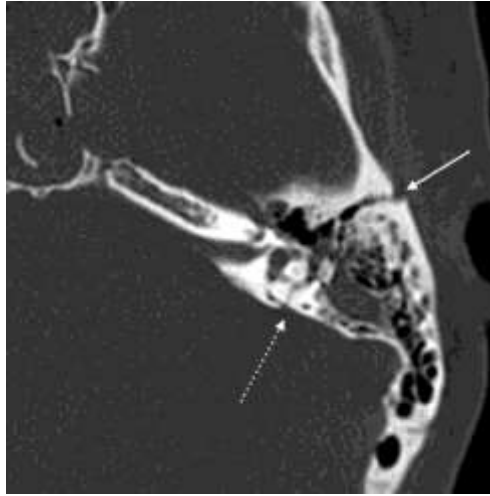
Mixed temporal bone fracture; axial MDCT scan (head trauma spiral CT protocol with 1mm thick slices) shows a longitudinal fracture line involving the left temporal bone pyramid base (arrow) and a transverse fracture line through the ipsilateral inner ear structures (dotted arrow).
